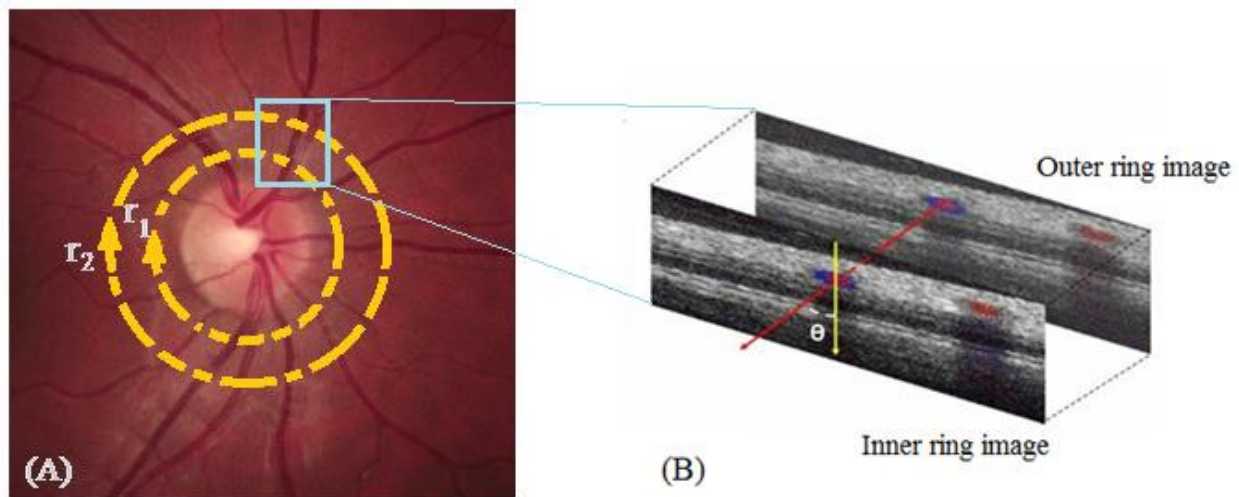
The blood flow double circular scan protocol. (A) Two concentric circles with different radius ($r_1 = 3.4\text{mm}$ and $r_2 = 3.75\text{mm}$) centred on the optic nerve head transecting all vessels traversing into and out from the eye. (B) OCT images corresponding from each circular scan pattern showing vessels with Doppler shift (blue and red colour dots). Doppler angle is measured between OCT beam line (yellow) and vessel line (red). Adapted from Wang et al.²¹⁸
